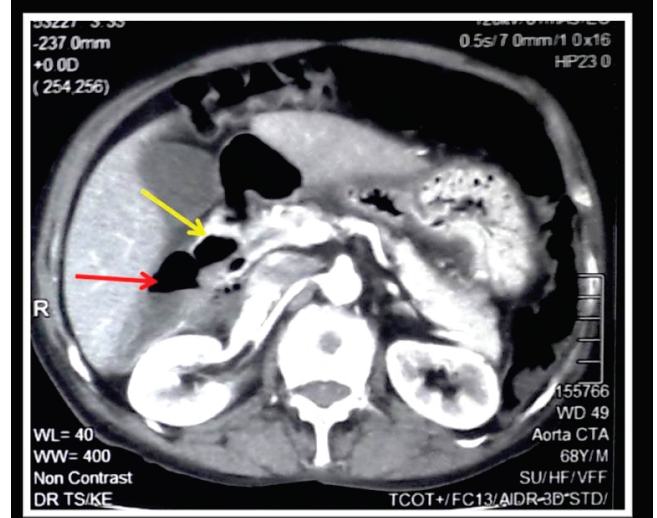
Contrast enhanced computed tomography scan image. Yellow arrow shows the diverticulum towards the pancreatic head region. Red arrow shows the second part of duodenum.
